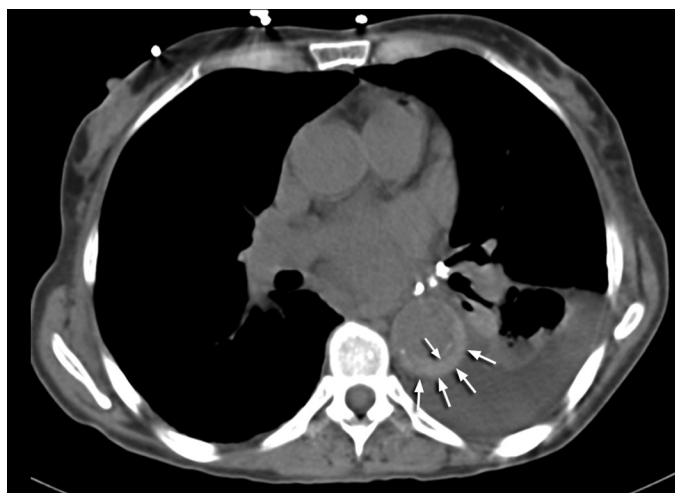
FIGURE e57-20 Non-contrast-enhanced CT scan revealing type B IMH with crescentic thickening of the aortic wall (*arrows*) and associated left pleural effusion.
